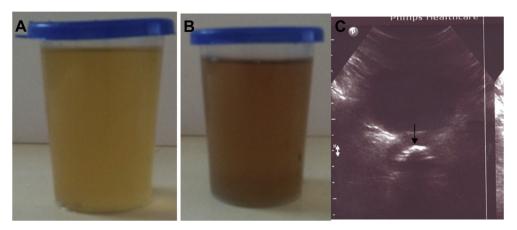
(A) Urine just after urination. (B) After 1 h exposure of sunlight. (C) Ultrasonography of pelvis revealed prostatic calcification.
